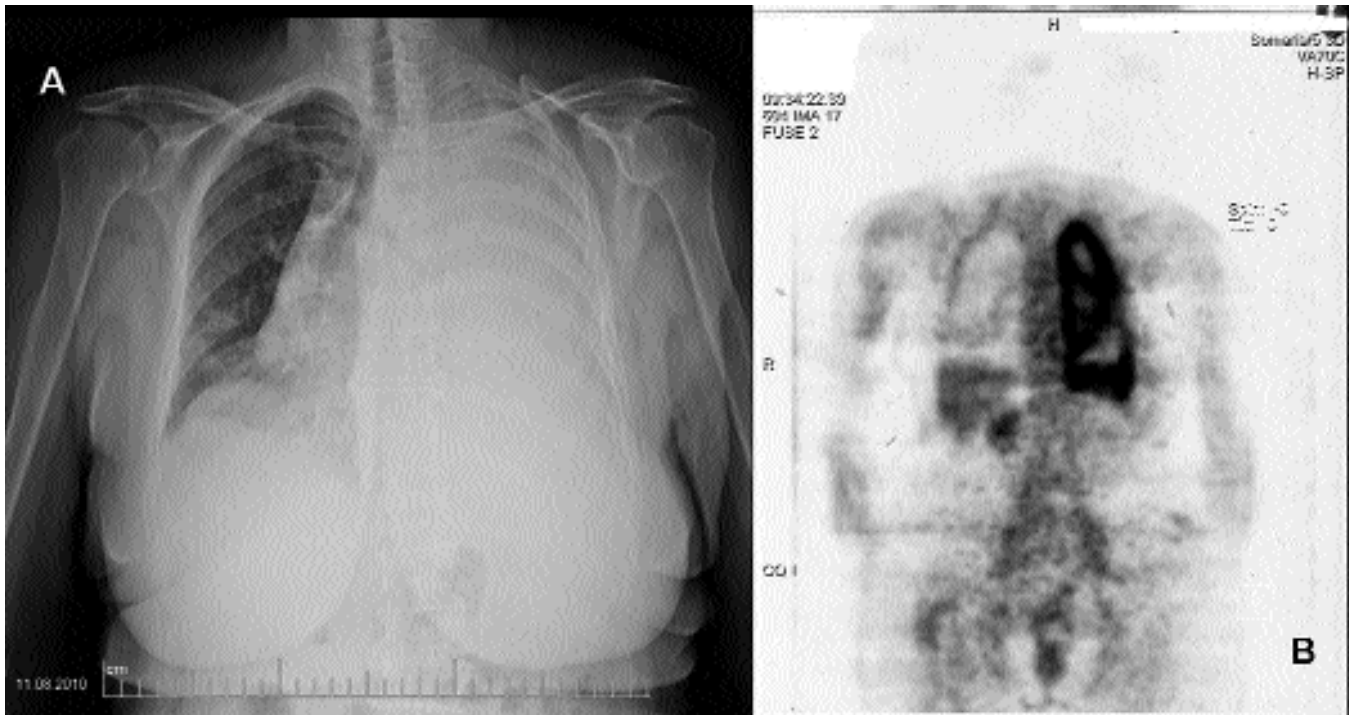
(a) Chest radiography. (b) PET/CT.
